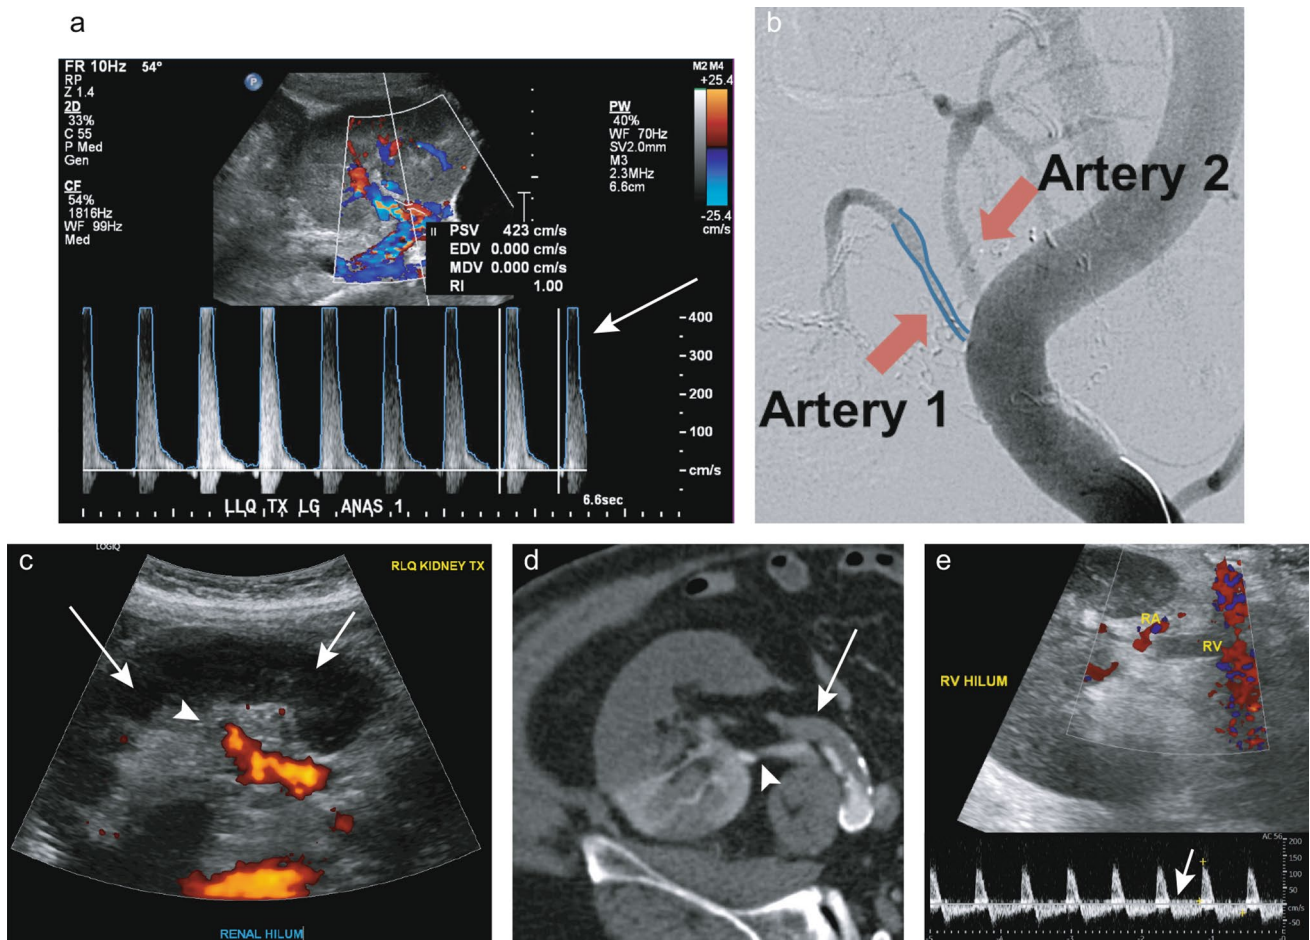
Vascular compromise. a Elevated peak systolic velocity > 400 cm/s (arrow) with resistive index of 1.00, followed by b digital subtraction angiography showing stenosis of one of the paired renal arteries while artery 2 is widely patent. c Renal artery thrombosis with power Doppler with absent flow in the renal parenchyma (arrow) and abrupt cutoff of the renal artery and minimal
